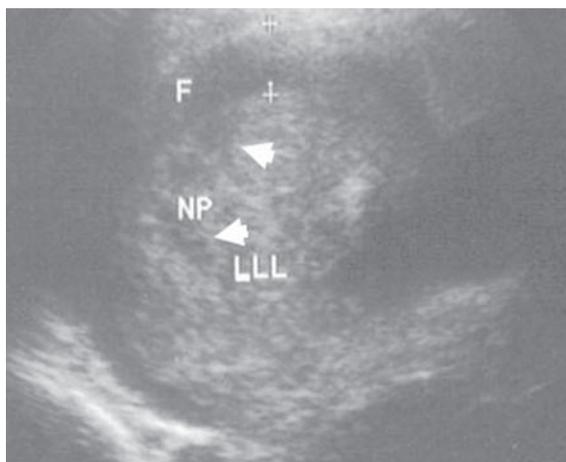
Transverse ultrasound scan of the left lingula lobe (LLL) obtained with the patient in the supine position at six days after fever showing multiple, peripheral, hypoechoic lesions with irregular outer margins (white arrow); this appearance is reflective of parenchymal necrosis. The sonolucent band corresponds to pleural fluid (F).
